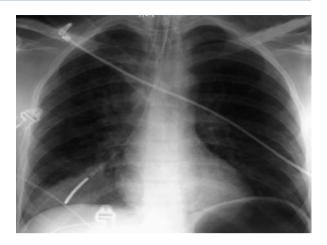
Chest X-ray AP showing subcutaneous emphysema and intercostal tube
